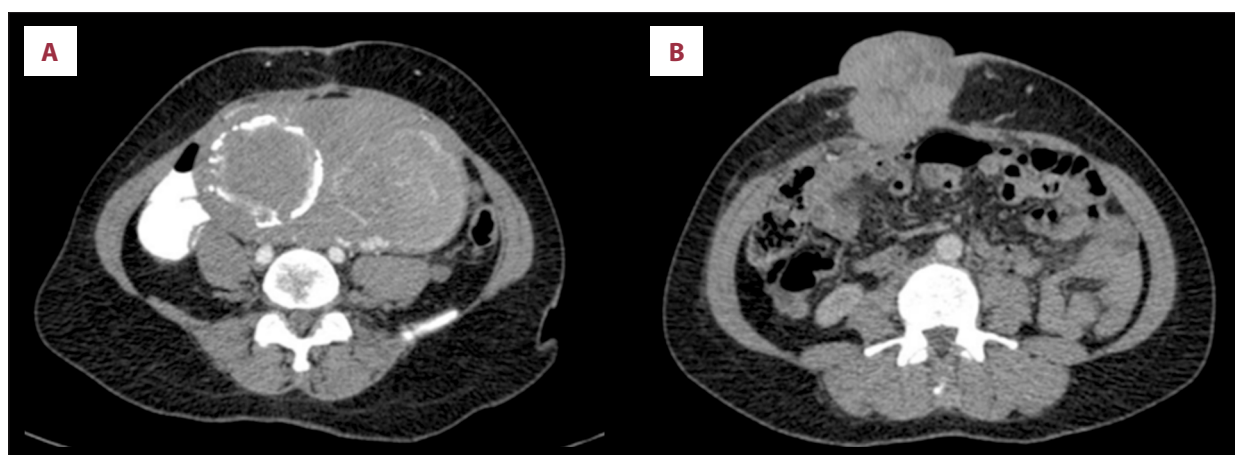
Abdomen and pelvis CT scans showing: (A) enlarged uterus due to fibroids (some with calcifications) and (B) infiltrative mass in the abdominal wall of the umbilical region.
